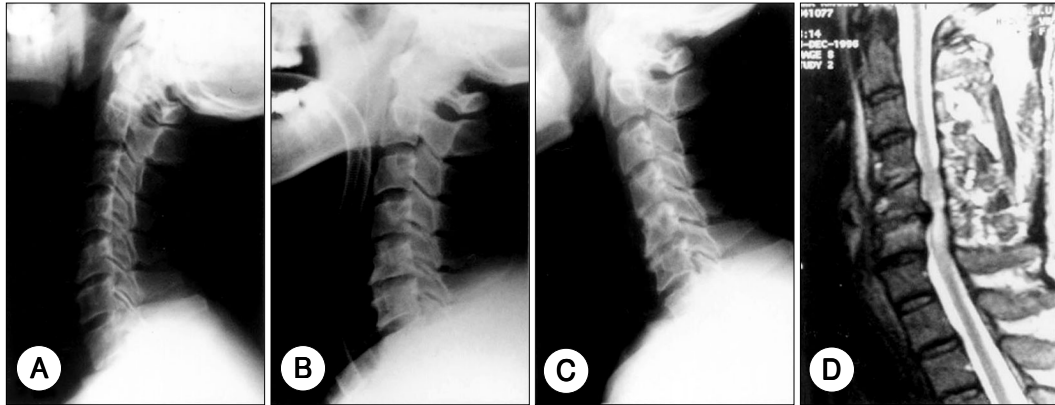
A case of graft dislodgement. A : preoperative cervical lateral film. B : postoperative cervical lateral film. C : the cervical lateral film at postoperative day 30 revealing graft dislodgement at C5-6. D : sagittal T2 weighted MRI at postoperative day 30 demonstrating posteriorly dislodged graft compressing the cord with high-signal intensity at C5-6 level.
